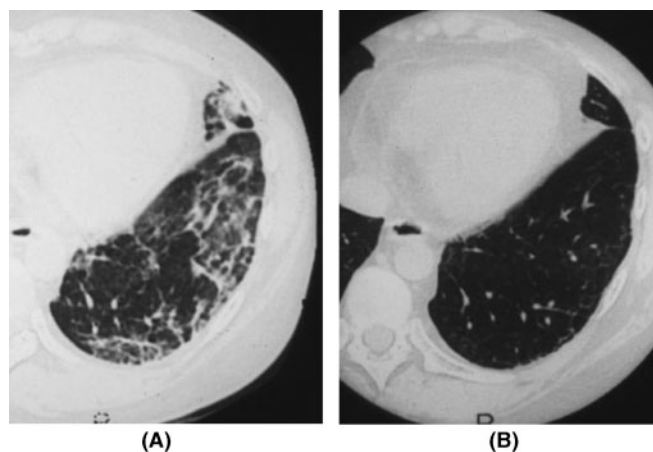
HRCT before and after the IVCYC therapy. HRCT of the case 2 before (A) and 2 yrs after the IVCYC therapy (B) is shown. Note the disappearance of linear opacity seen in (A) in HRCT 2 yrs later (B).
